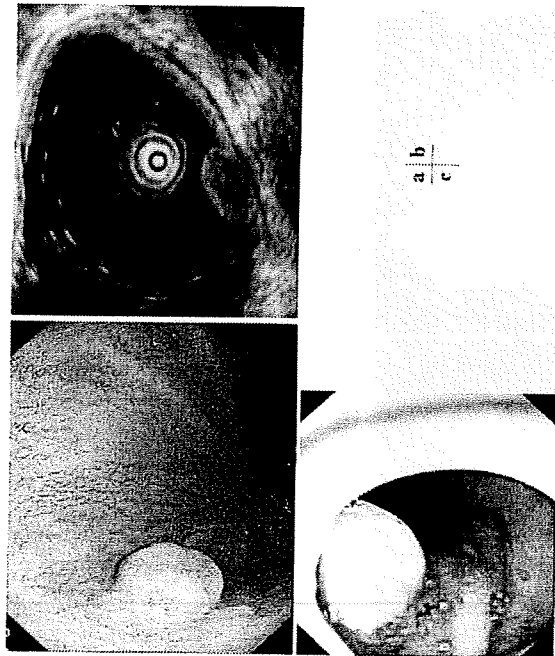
Endoscopic findings (case 2). a. Duodenal carcinoma in the anterior wall of the bulb. b. Endoscopic ultrasonography: The tumor was confined to the submucosal layer. c. Intraoperative endoscopy after ICG injection.
